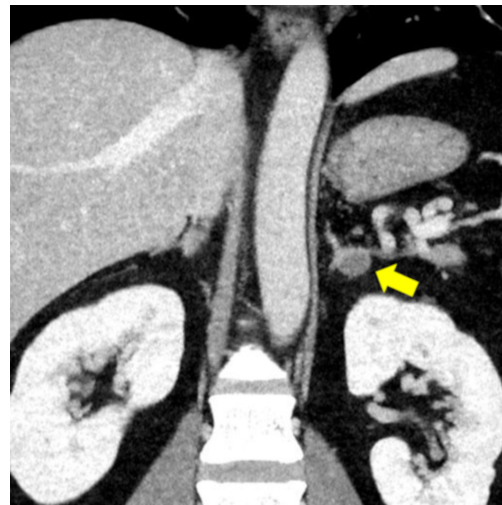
Enhanced computed tomography reveals a 15-mm well-defined tumor with low attenuation in the left adrenal gland (yellow arrow).
